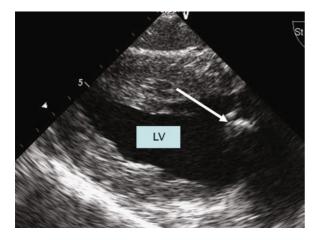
Ruptured papillary muscle in a patient with acute inferior wall MI. Color Doppler demonstrated severe MR
